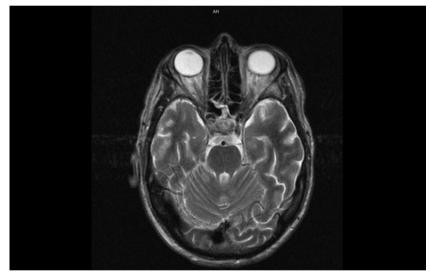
Brain MRI March 2014(a).
